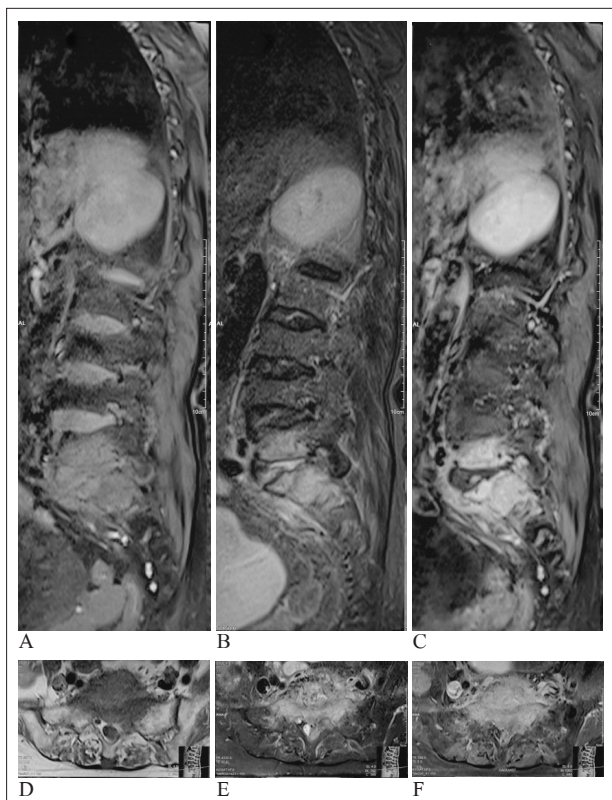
Magnetic resonance imaging with fat suppression in sagittal view A) T1-weighted B) T2-weighted C) T1-weighted with gadolinium and in coronal view D) T1-weighted E) T2-weighted F) T1-weighted with gadolinium demonstrated enhancement of L5-S1 vertebral bodies.
